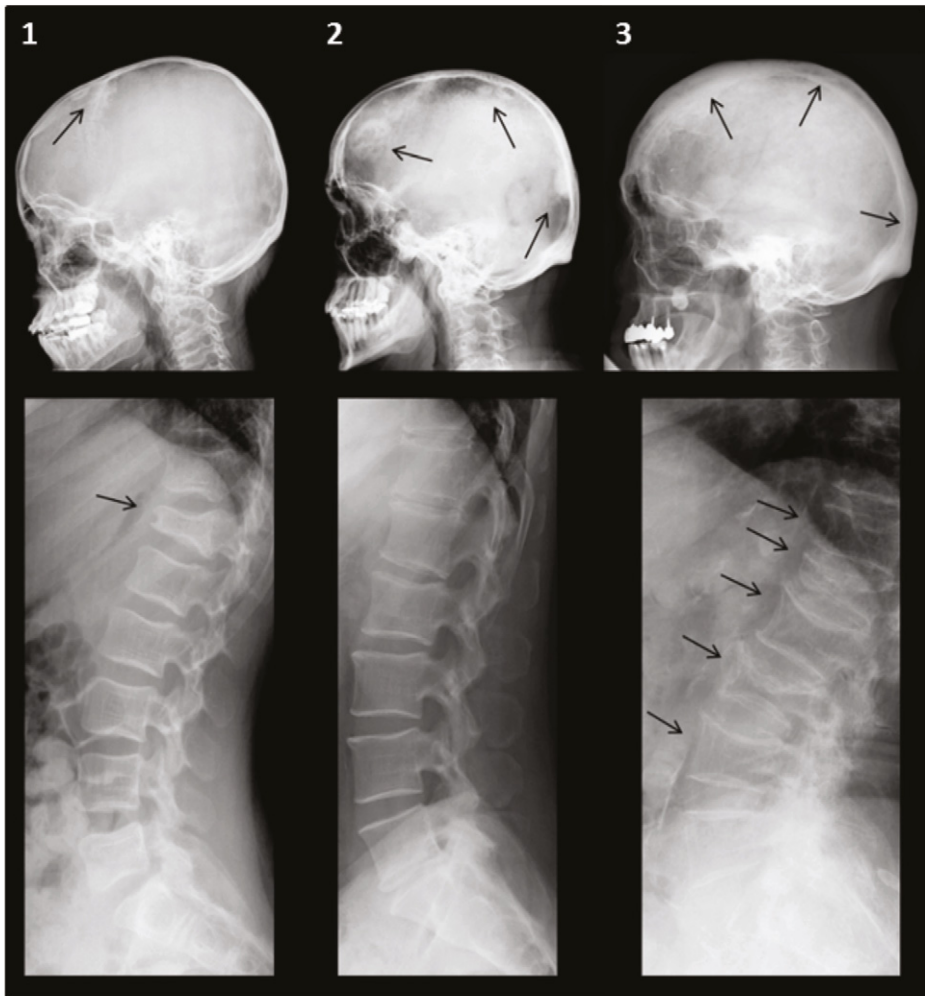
Skull and lumbar spine radiographs of the affected family members; changes are indicated with arrows. (1) The index patient has sclerosis around and anterior to the coronary suture and a thoracic VCF. (2) The father's radiograph reveals multiple CDLs. He has no obvious lumbar spine changes. (3) The paternal grandmother has generalized irregular hyperostosis of the skull and multiple severe lumbar VCFs.
